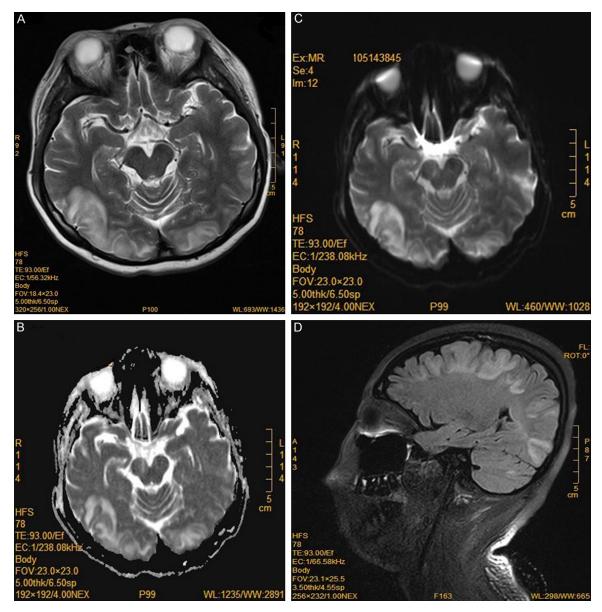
(A) T2 weighted: T2-weighted sequences involving the cortical and subcortical regions of parietooccipital lobes. (B) ADC map showed an increase of the apparent diffusion coefficient (ADC) value, suggestive of vasogenic edema in the same regions. (C) Diffuse weighted image (DWI). (D) Fluid-attenuated inversion recovery magnetic resonance imaging (FLAIR) MRI image. Brain MRI image of the patient showed high intensity involving the cortical and subcortical regions of the parietooccipital lobes in T2 weighted, DWI, and FLAIR (A, C, D).
